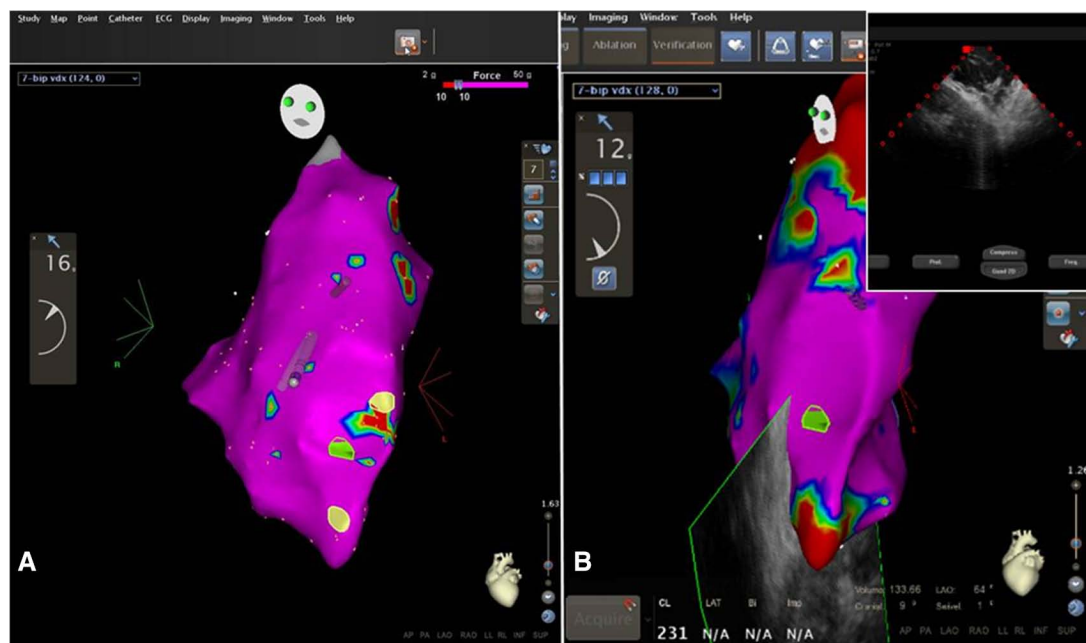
A, Right ventricular (RV) force map with the cutoff set at 10 g B, CARTO Sound image during reconstruction of endocardial unipolar voltage map (cutoff at 5.5 mV); the intracardiac echocardiography allows to visualize the RV wall and to check the mapping catheter contact.
